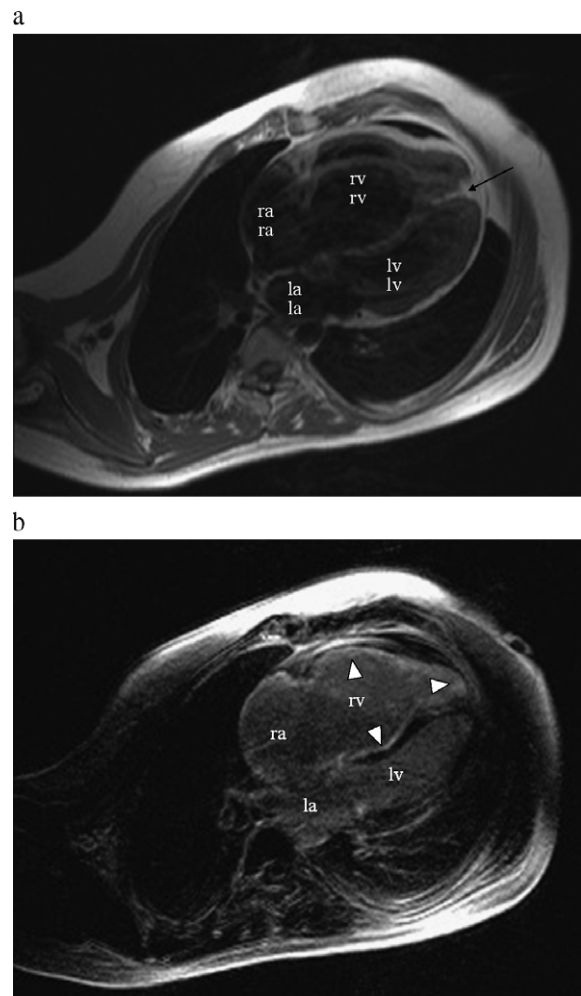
(a) Cardiac magnetic resonance imaging (MRI) is showing fatty infiltration at the apex (black arrow). ra: right atrium, la: left atrium, rv: right ventricle, lv: left ventricle. (b) MRI obtained at the 15 min after contrast injection indicating fibrosis at the right ventricular lateral wall, apex and the right ventricular side of the septum (arrow). ra: right atrium, la: left atrium, rv: right ventricle, lv: left ventricle.
